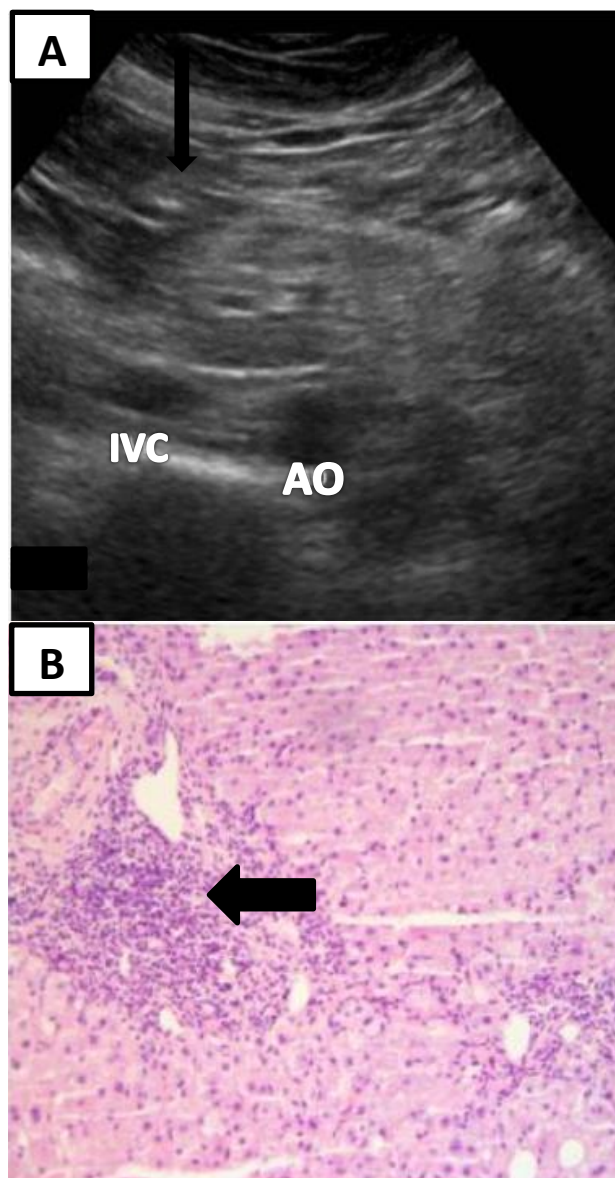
A) Abdomen ultrasonography showed mild to severe steatosis in liver parenchyma and mild severe mesenteric panniculitis in the mesenteric root periphery (black arrow), IVC: inferior vena cava, AO: aorta abdominalis, B) mild stage fibrosis was observed in the liver biopsy (black arrow)
